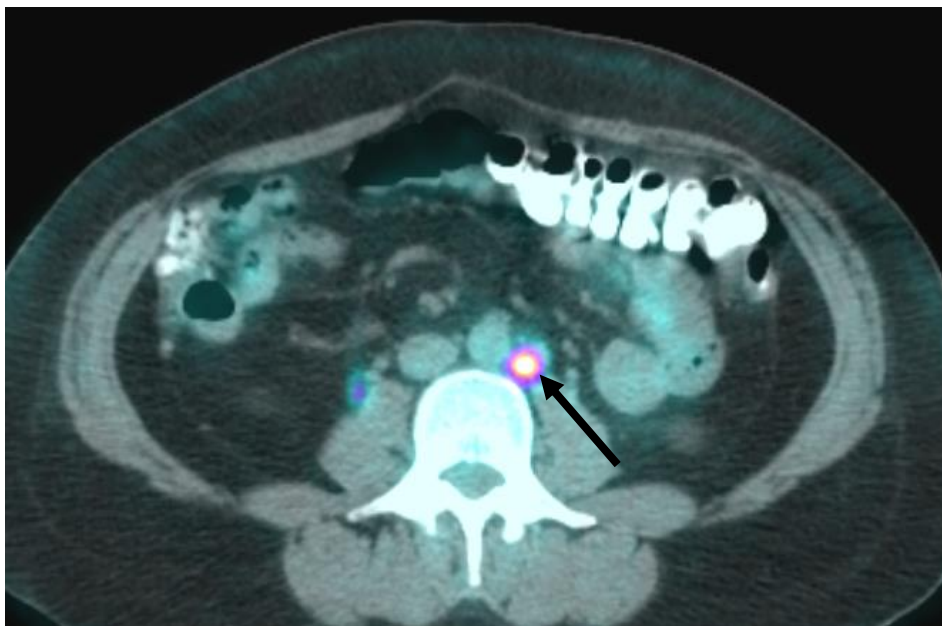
Example anonymised transverse FDG-PET/CT image highlighting a positive para-aortic node (arrowed).
